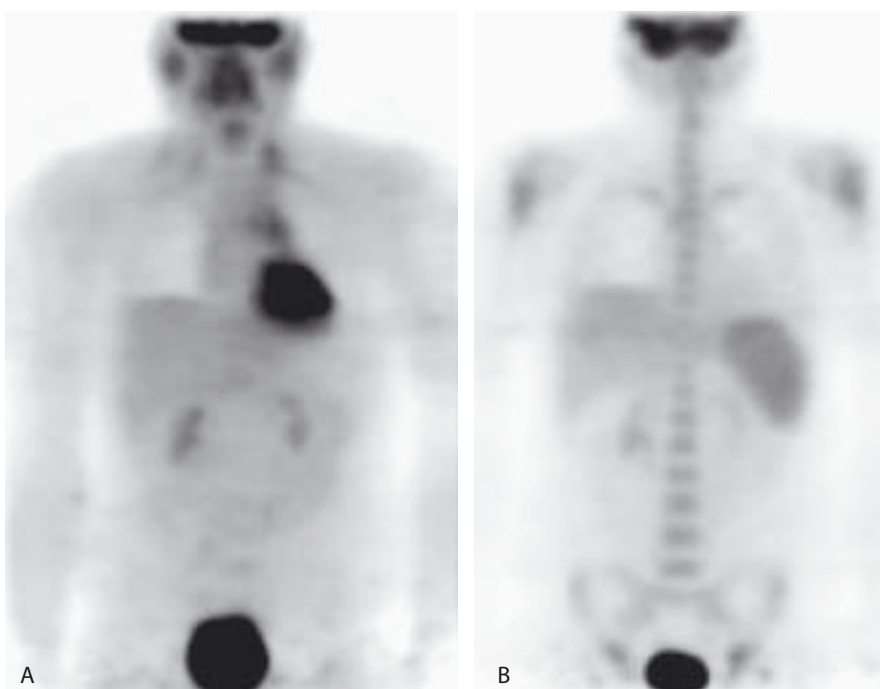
A 17-year-old boy with stage IIA nodular sclerosing Hodgkin's disease. A: Pretreatment PET demonstrates FDG uptake in the left neck and mediastinum. B: On the follow-up PET, performed after two cycles of chemotherapy, the neck and mediastinal abnormalities have resolved. There is homogeneously increased FDG activity in the bone marrow and spleen. Increased marrow and splenic activity, which is often observed after treatment in patients with lymphoma, is due to the effects of colony-stimulating factors on the hematopoietic system.
